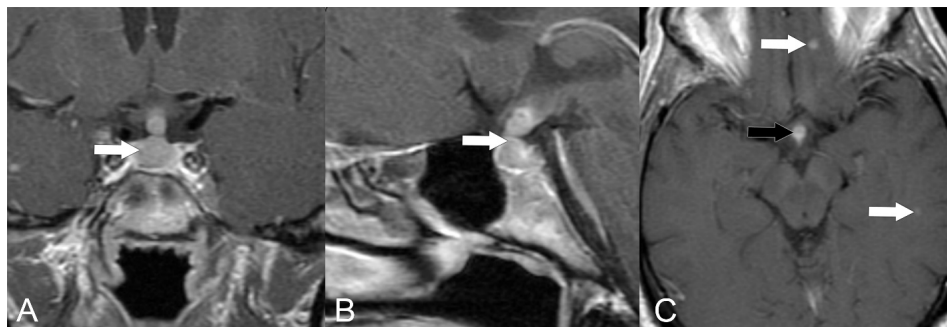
A 61-year-old male with a pituitary metastasis from papillary thyroid carcinoma. (A,B) Coronal and sagittal T1 post-contrast MRIs show a homogeneously enhancing metastasis involving the pituitary gland with narrowing of the mass at the diaphragma sella and thickening of the infundibulum (arrows). (C) Axial T1 post-contrast MRI shows metastases in the brain parenchyma (white arrows) and the pituitary infundibulum (black arrow).
